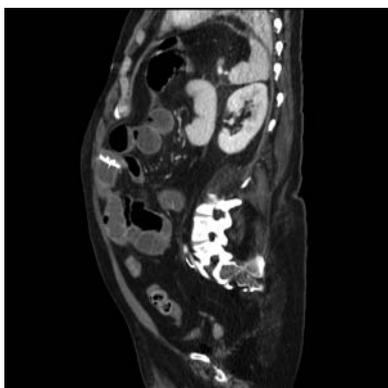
Postintravenous contrast sagittal abdominal CT image. This demonstrates the transition point in the small bowel caused by the percutaneous endoscopic gastrostomy flange.
